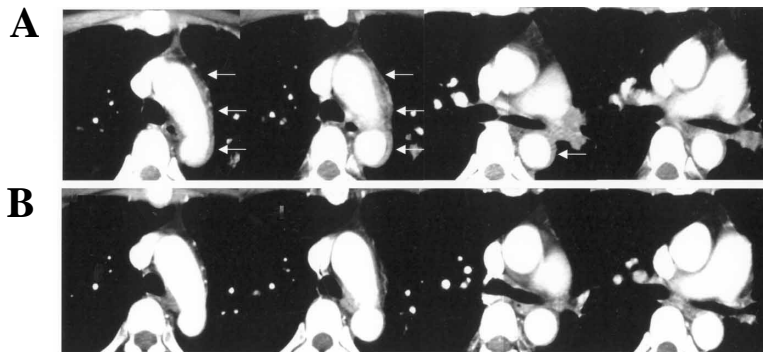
Computed tomography. A: Before treatment. White arrows show segmental wall thickening in the thoracic aorta. The proximal part of the left pulmonary artery is occluded. B: Two months after starting steroid therapy, the wall thickening in the aorta had disappeared.
